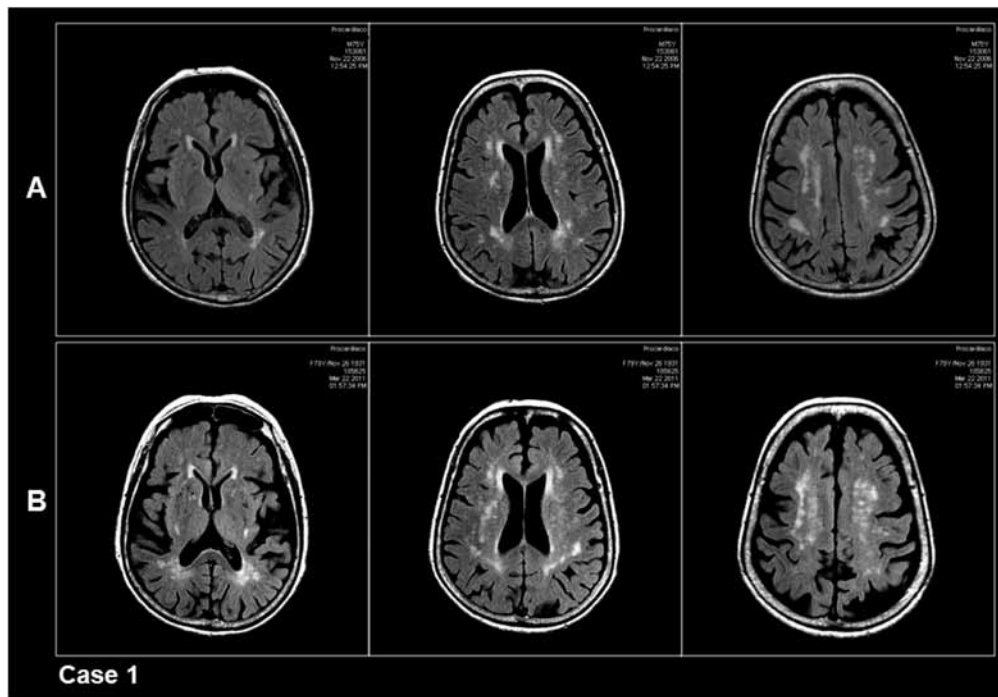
Case 1. MRI-FLAIR acquisition of three representative axial sections that show WMH burden. A: mFazekas score = 2; B: mFazekas score = 3.
